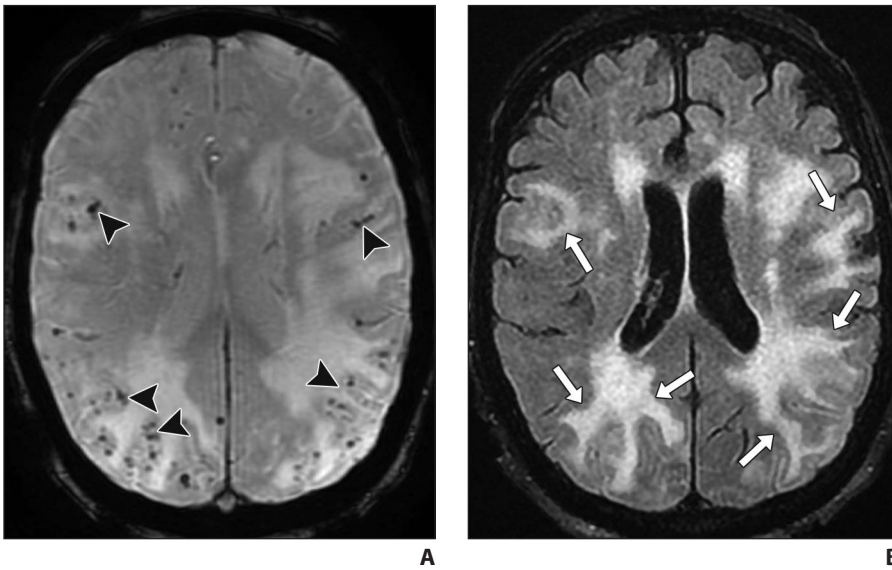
Inflammatory cerebral amyloid angiopathy. A and B, Axial susceptibility-weighted (A) and FLAIR (B) MR images in patient presenting with progressive cognitive decline. Numerous widespread foci of chronic microhemorrhage (*arrowheads*, A) are associated with confluent areas of vasogenic edema (*arrows*, B), suggesting inflammatory cerebral amyloid angiopathy. Areas of edema resolved with steroid therapy.
